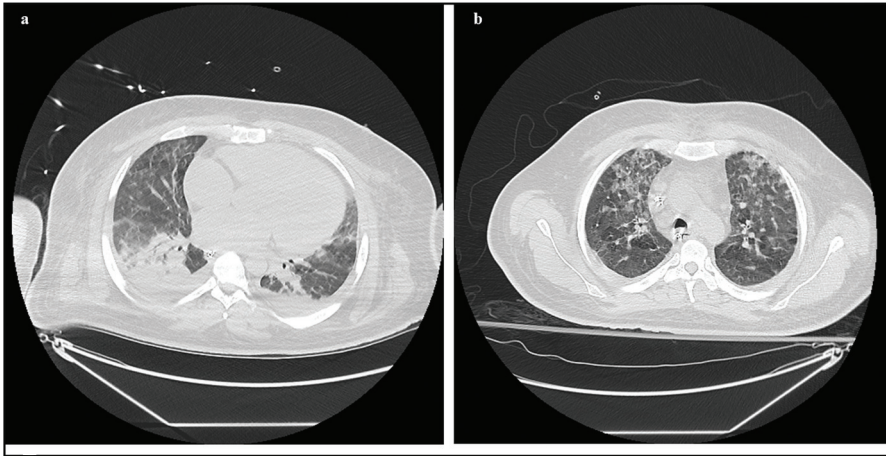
Computed tomographies (CT) of the chest. (a) Bilateral lower lobe consolidation, multifocal ground-glass opacities, pleural effusions, and cardiomegaly obtained during the initial episode of hypoxemic respiratory failure. (b) Bilateral upper lobe airspace disease and interstitial thickening obtained 20 days into hospitalization during the patient's second episode of respiratory distress.
